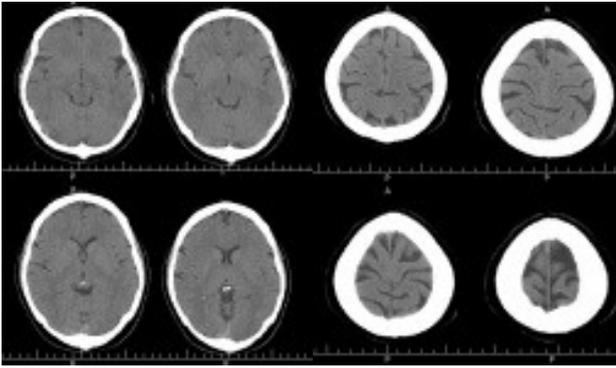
Initial normal brain CT scans of patient after headache onset
